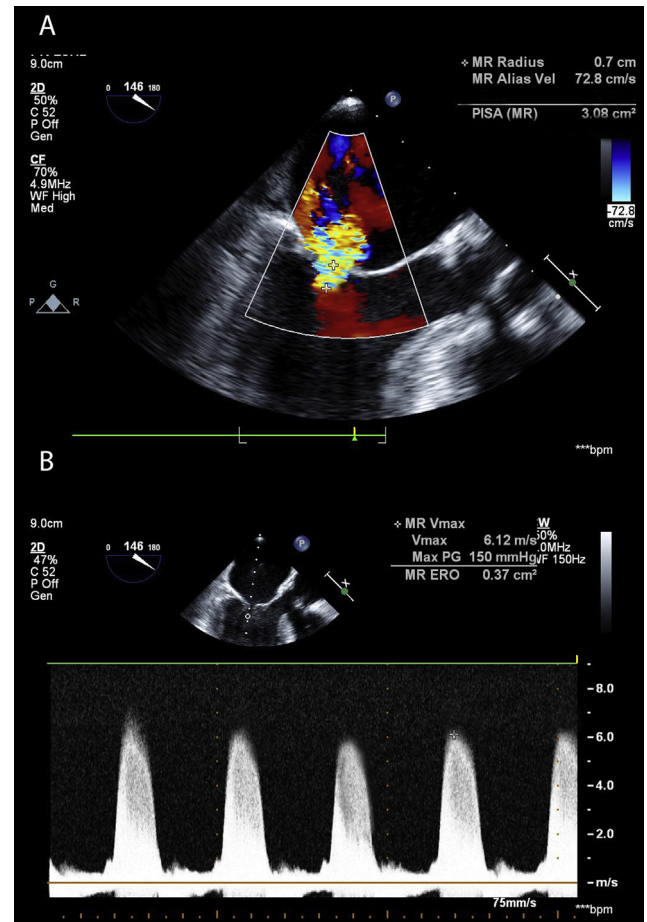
Measurement of the EROA by the flow convergence method. (A) Color Doppler imaging demonstrating a flow convergence zone on the left ventricular side of the valve in late systole (midesophageal long-axis view). The PISA radius is measured from the tip of the mitral leaflets in late systole to the point of first aliasing. (B) Continuous-wave Doppler imaging through the mitral leaflets demonstrating the peak regurgitant velocity of the regurgitant jet (midesophageal long-axis view). In this example, the PISA radius is 7 mm, the NL is 72.8 cm/sec, and V_{MR} is 6.12 m/sec, yielding an EROA of 37 mm² (i.e., moderate to severe MR).
